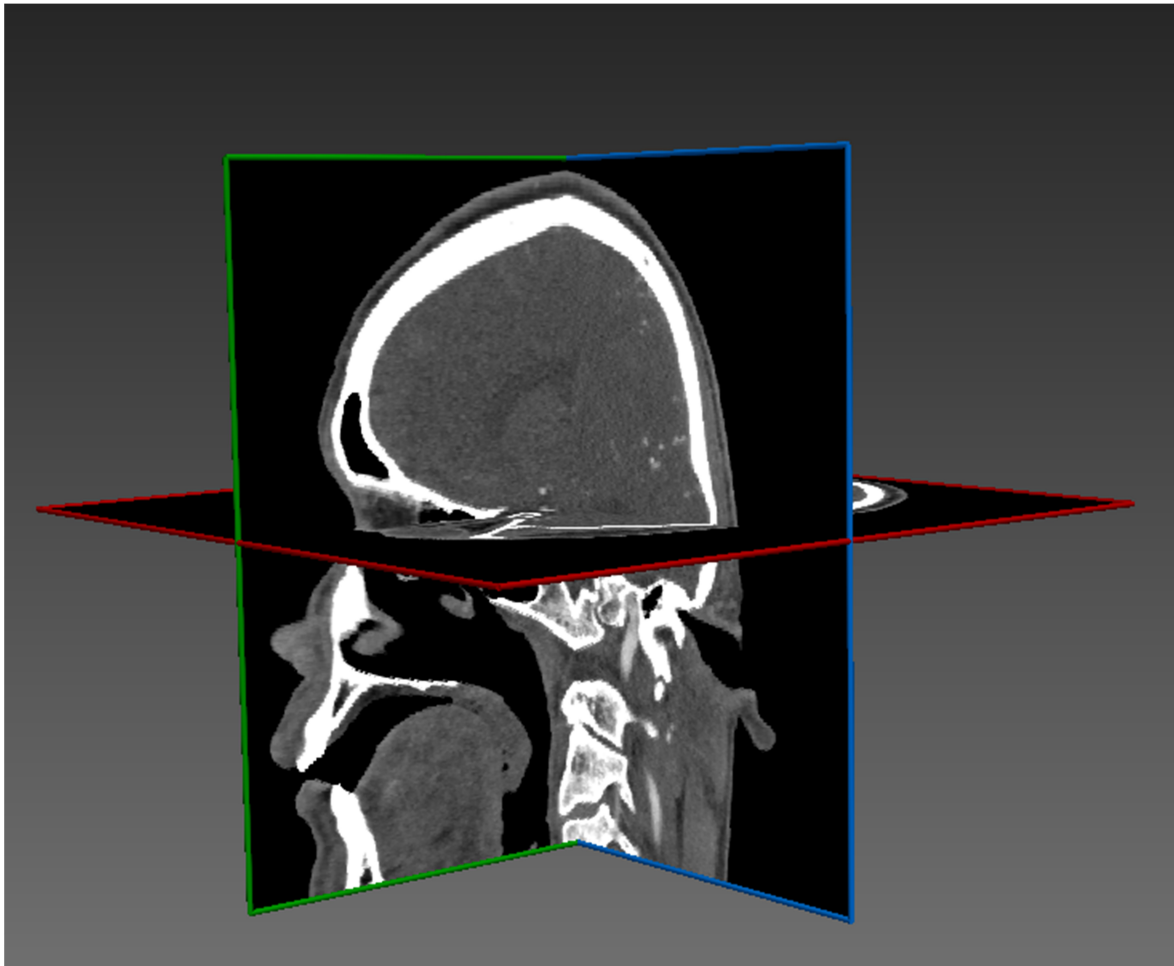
Computed tomographic angiography (CTA) of the brain
